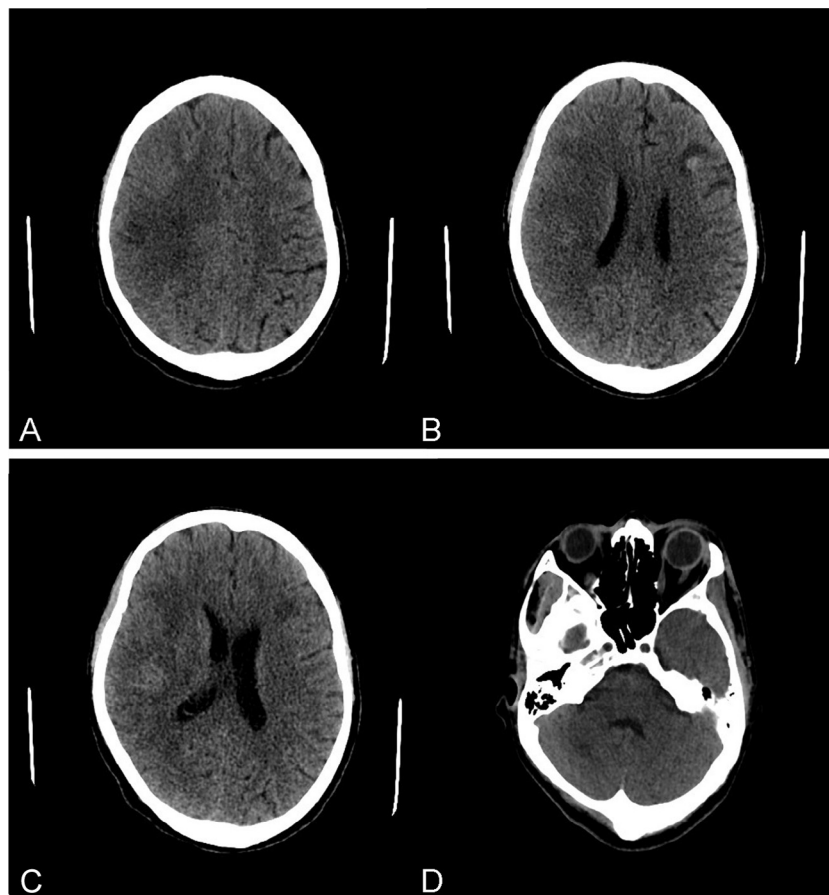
Plain brain CT axial slices: (A) Presence of ill-defined hypodensities in the gray-white matter junction in the right frontoparietal area. (B and C) Note the edema and effacement of the cortical sulci. There is a small ill-defined hypodense area seen in left frontal lobe at the gray-white matter junction containing small hemorrhagic component. (D) Display of a right cerebellar ill-defined hypodensity.
